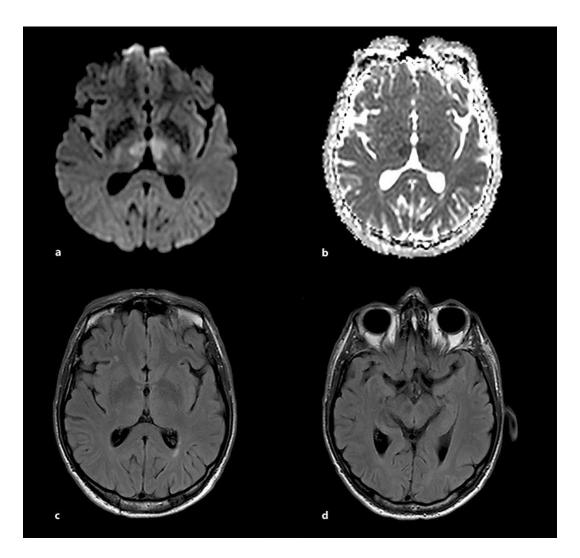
MR brain images showing the mismatch between positive DWI (a, b) and negative FLAIR (c, d), consistent with hyperacute stroke of the AOP vascular territory.
